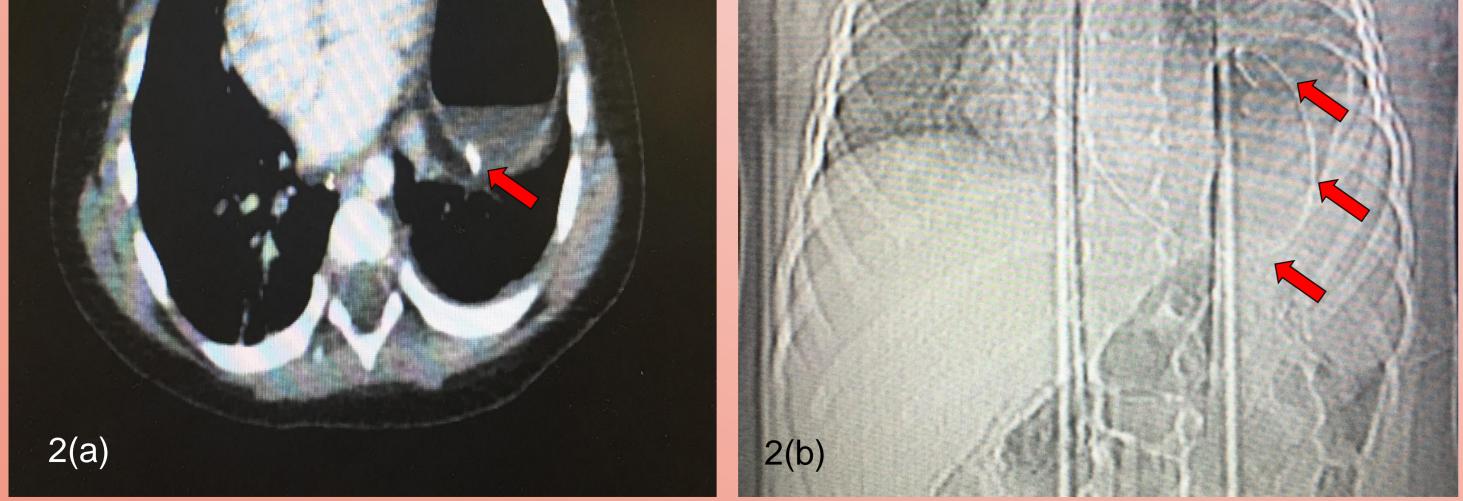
(a) Computed tomography thorax showing stomach in the left thoracic cavity with nasogastric tube (arrow) in-situ. Nasogastric tube (arrow) can be seen inside the left lung field in Fig 3(b)
